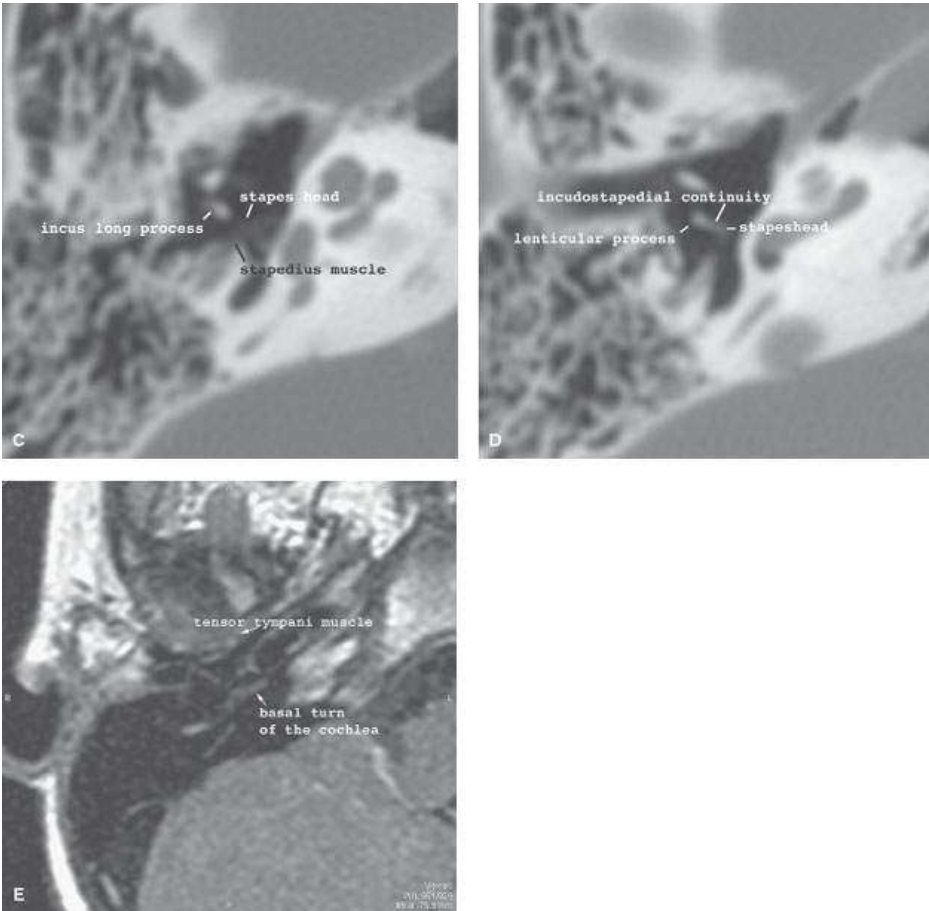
Normal appearance of the ossicular muscles. The tensor tympani muscle runs from the auditory tube to the long process of the malleus (A, B). The stapedial muscle originates at the pyramidal eminence and attaches to the stapes posterior crus (A, B) or head (C, D). The tensor tympani is consistently visible on magnetic resonance imaging (E).
